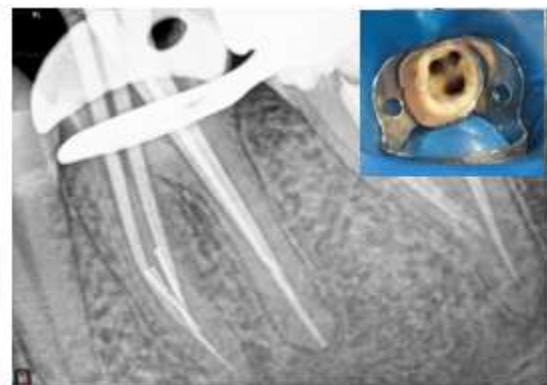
Master cone Radiograph
